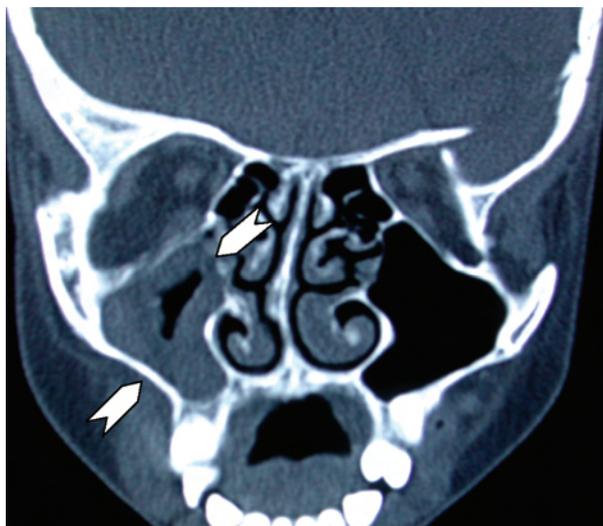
Coronal CT of case 1 showing obliteration of the right sinus causing blockage of the medial conchae and extension to the right ethmoid sinus (arrowhead)
